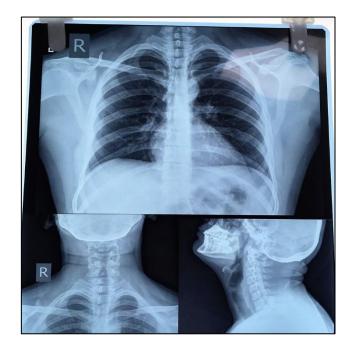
Radiograph of the chest of no gross abnormalities.
